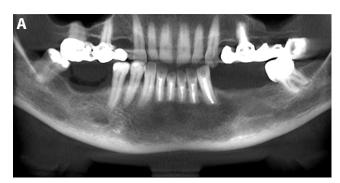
A – orthopantomogram taken 2.5 years after the conservative surgical intervention, showing a mandibular keratocyst recurrence in the area of teeth 42–35; B – selected coronal sections of cone-beam computed tomography (CBCT) 2.5 years after the conservative surgical intervention, showing well-defined oval osteolysis beneath the previously resected root apices of teeth 42, 41, 31, 32, and 33 (keratocyst recurrence)
